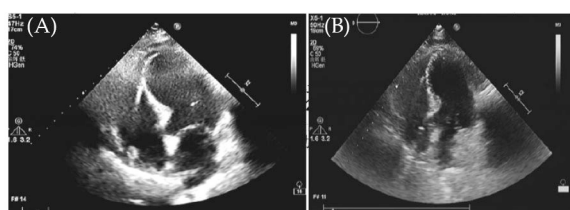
The representative echocardiography of this patient. (A): The same patient developed apical ventricular aneurysm in the early stage; and (B): apical ventricular aneurysm of the same patient disappeared and heart function recovered.
